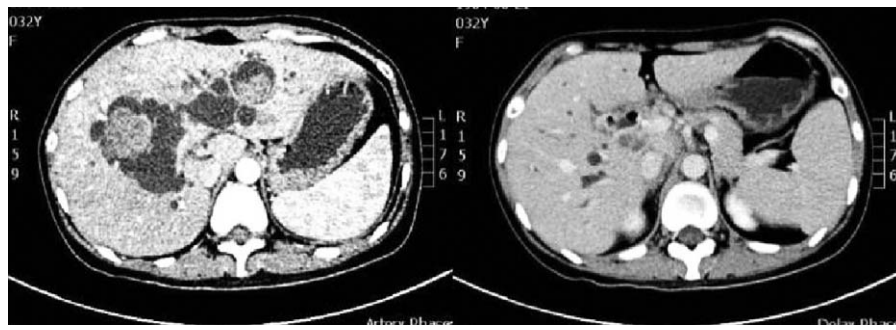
Contrast-enhanced CT showing cystic dilatation of intrahepatic bile ducts containing multiple stones (A). Presence of soft tissue lesion at the hepatic hilum, replacing the common hepatic duct (B). CT = computed tomography.
